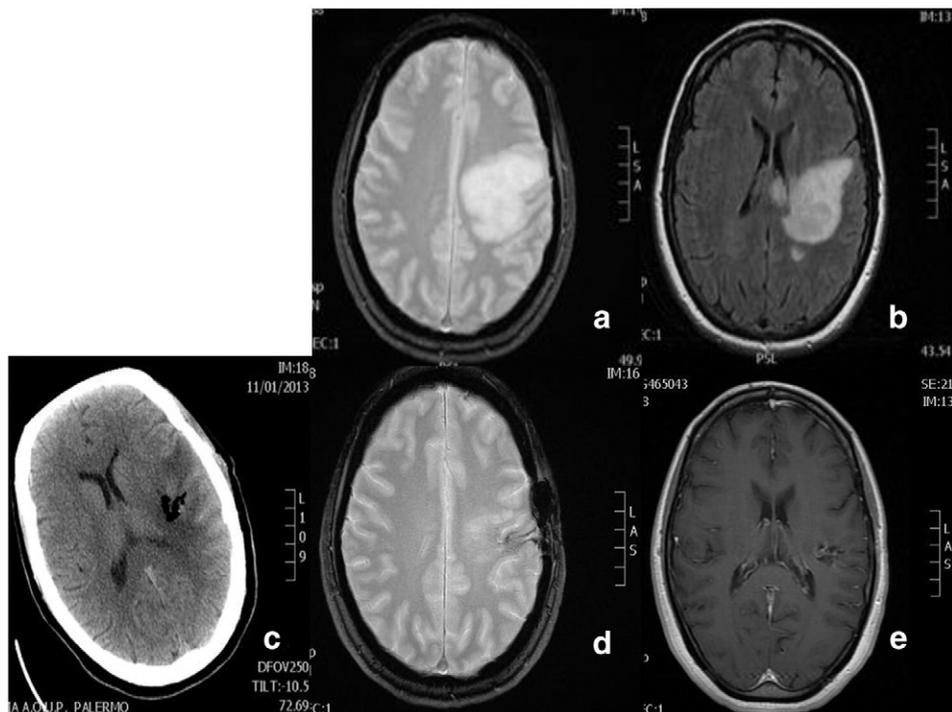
a–b: Pseudotumoral aspect of the left fronto-parietal lesion. c: Immediate postoperative CT scan. d–e: Nine-month follow-up brain MRI scan showing no signs of progressing demyelinating disease and almost complete retrogression of the other two lesions.
